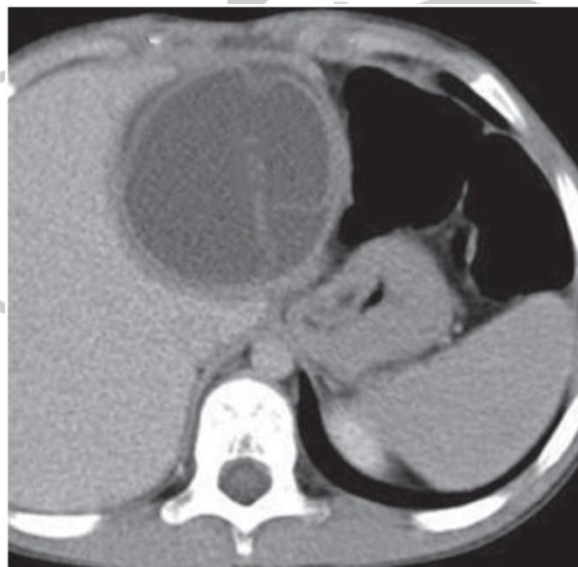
Hydatid infection Contrast-enhanced axial CT image shows well-defined cystic mass with several internal endocyst membranes.
